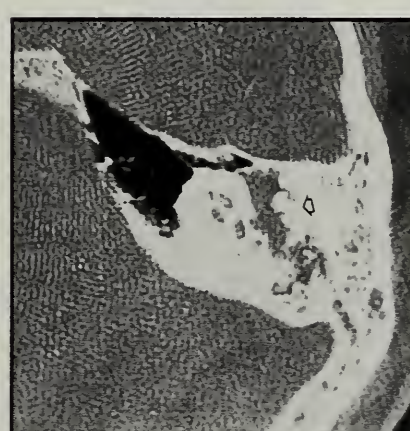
Axial CT image at the middle ear.
